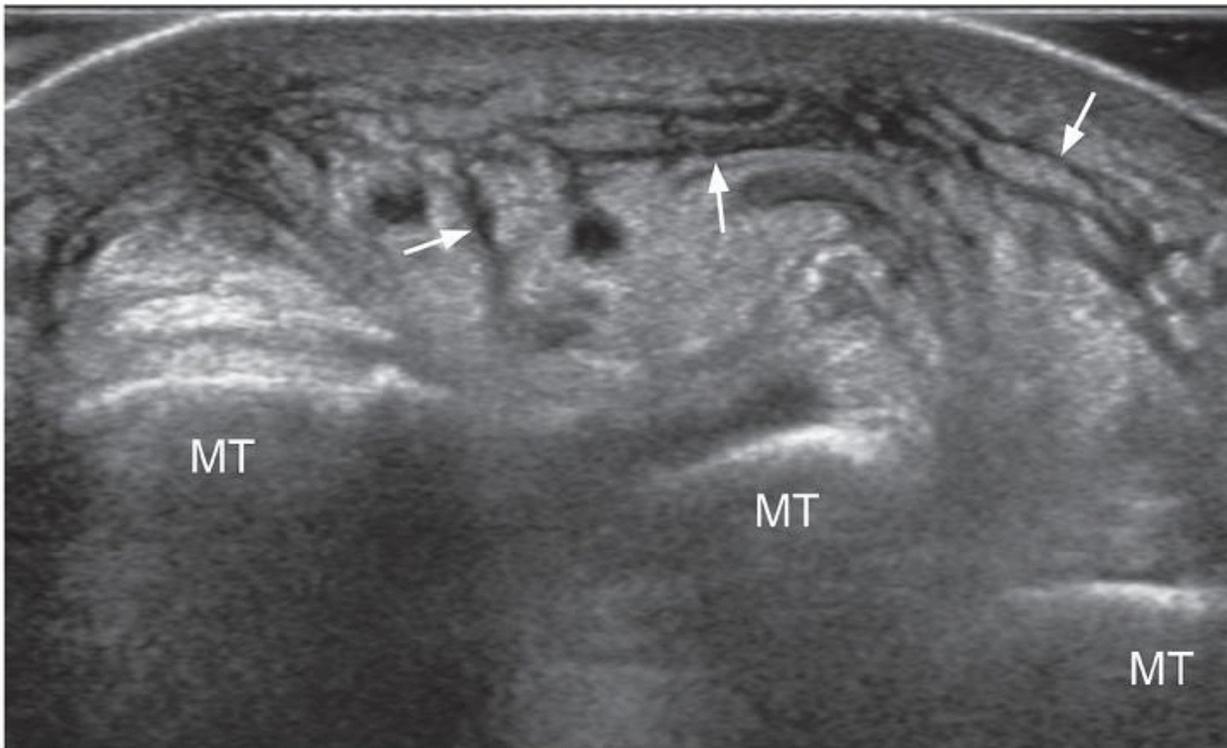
Transverse ultrasound of dorsum of forefoot. Severe edema of the subcutaneous fat is present with edematous thickening of the interlobular septa (arrows). Moderate hyperemia was present on color Doppler imaging. No discrete collection. Overall appearances are consistent with severe cellulitis. MT, metatarsal bones.
